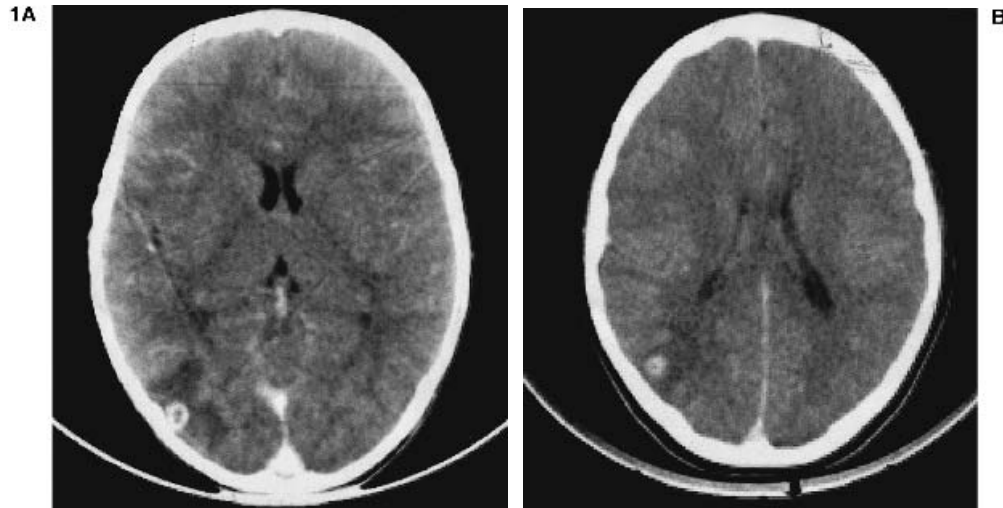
Contrast-enhanced CT scans showing a “ring” (A) and a “disk” (B) lesion with edema.
